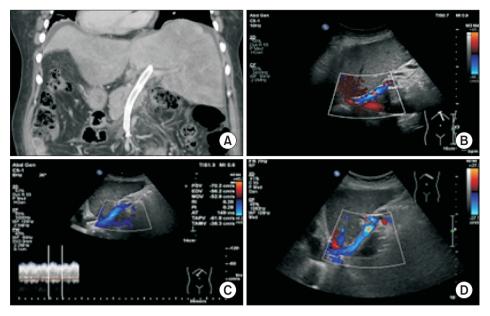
(A) Computed tomography scan and ultrasonography showing the patency of blood flow in the stent and significant improvement in portal perfusion over with the image taken before the procedure. The flow rate in the stent observed three days (B), one month (C), and three months (D) after the procedure taken by ultrasonography were 171 cm/s, 70 cm/s, and 93 cm/s.
